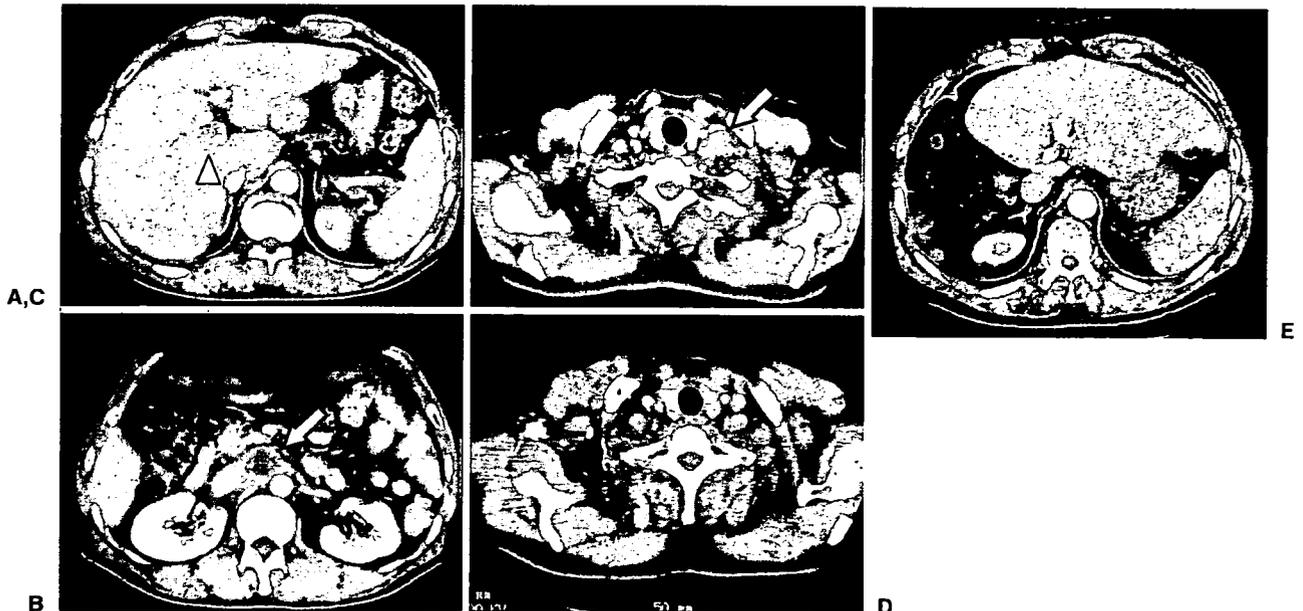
Computed tomography (CT) of case 1. A The main tumor, 6.0cm in size, is located in the right lobe of the liver, and the tumor thrombus has invaded the right main branch of the portal vein (*arrowhead*). B Paraaortic lymph node enlarged, 2.5cm in size (*white arrow*). C Chest CT scan shows an enlarged subclavicular lymph node to 2.0cm (*white arrow*). D After three cycles of interferon- α /5-fluorouracil combination therapy, the subclavicular lymph node had vanished. E There was no residual tumor or recurrence in the remnant liver 56 months after the first treatment
